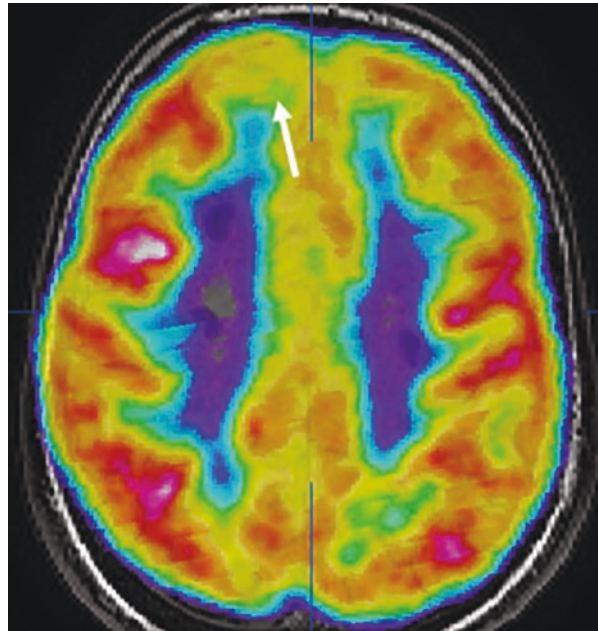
Ictal SPECT co-registered to MRI with marked hyperperfusion in the right middle frontal gyrus
